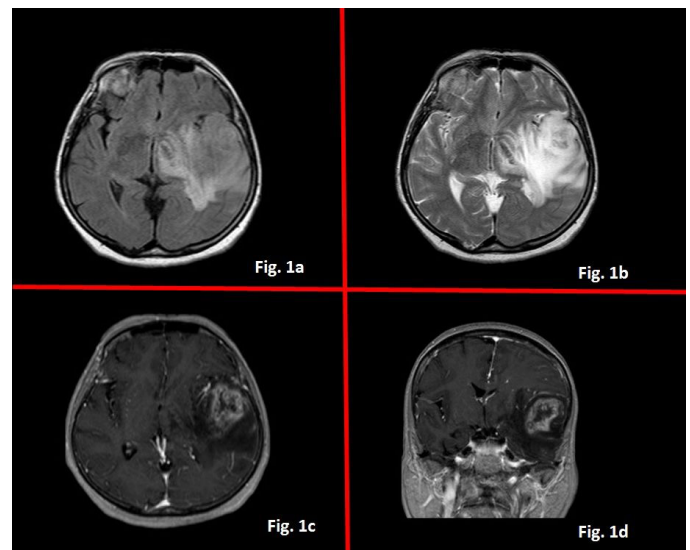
Cranial MRI of the patient before the first surgery. T1 axial (1a), T2 axial (1b), contrast-enhanced T1 axial (1c), and contrast-enhanced T1 coronal (1d) views. A 5x4.5 cm diffuse mass lesion in the temporal area was detected
